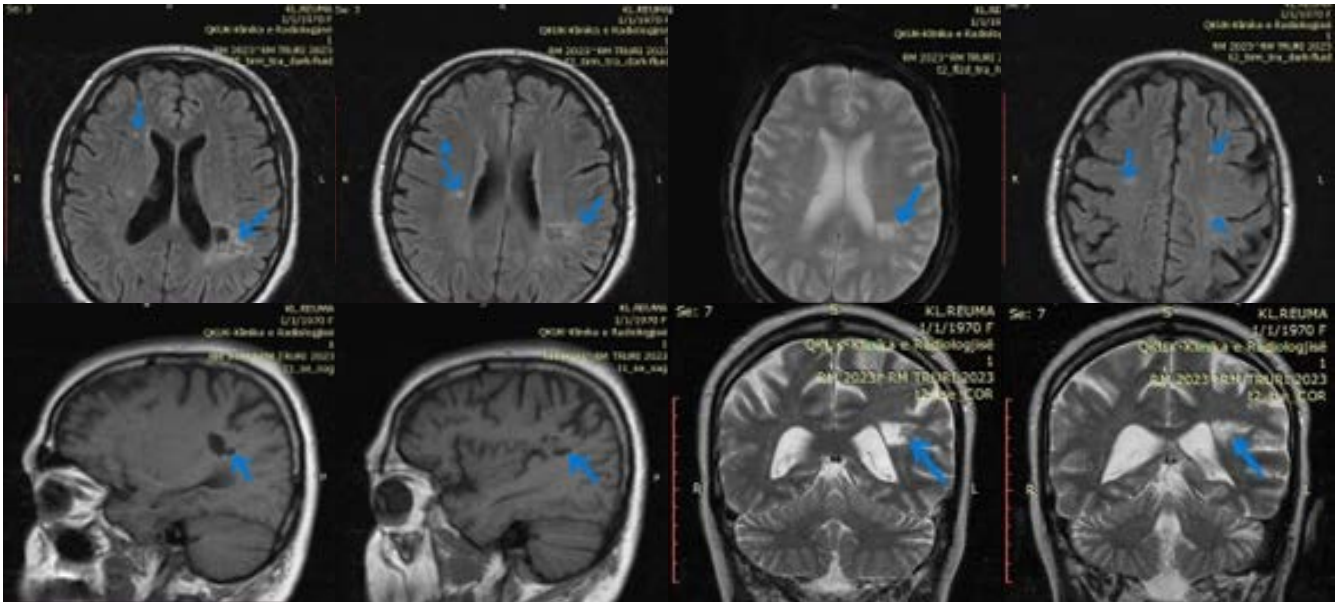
MRI of the head with signs of chronic ICV, signs of subacute ischemia and mild cerebral atrophy. Chronic ischemic changes are seen in the left parietal periventricular region with dimensions of about 12 mm. A millimetric (3.5 mm) paraventricular lesion is also seen in the right frontal white mass, which corresponds to a subacute lesion. In the periventricular region and in the bilateral frontoparietal deep white matter, millimetric lesions are seen that respond to gliotic changes as a consequence of chronic microvascular disease.
